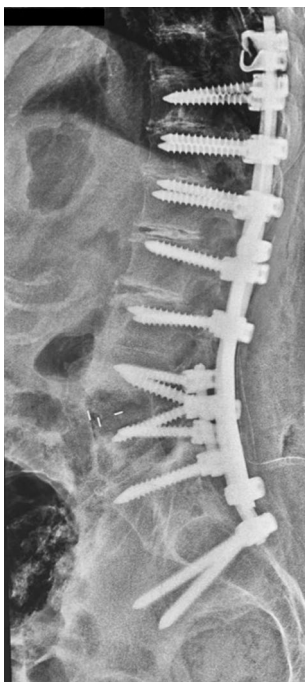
Immediate postoperative thoracolumbar X-ray confirming the good position of the cage in L4/L5 with correction of the thoracolumbar kyphosis
